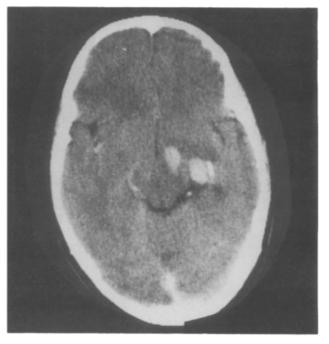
Computed tomography scan findings. (Left) Case no. 2. Computed tomography idiosyncrasies of a PXA: a parietal located, partly cystic tumor, firmly connected with the dura. (Right) Case no. 5. Cystic tumor with deep temporal location, extending into the thalamus. No connection with the dura is noted.
